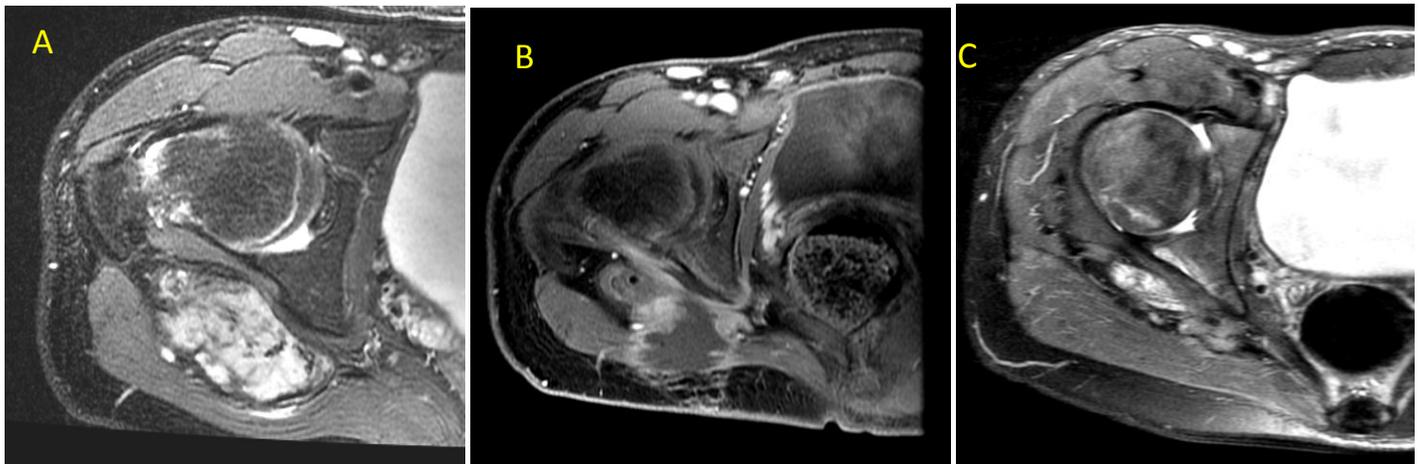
Twelve year old boy who had (A) an enlarging desmoid tumor of his right buttock as seen on this T2 weighted MR image. He had local recurrences after two operations including a left above knee amputation. He had stable disease while on chemotherapy but progressive disease when he stopped systemic treatment. He underwent two MRgHIFU treatments with (B) T1 fat suppressed post contrast MRI showing necrosis of the tumor and (C) near complete resolution of the tumor as seen on a 4 month followup T2 weighted MRI.
